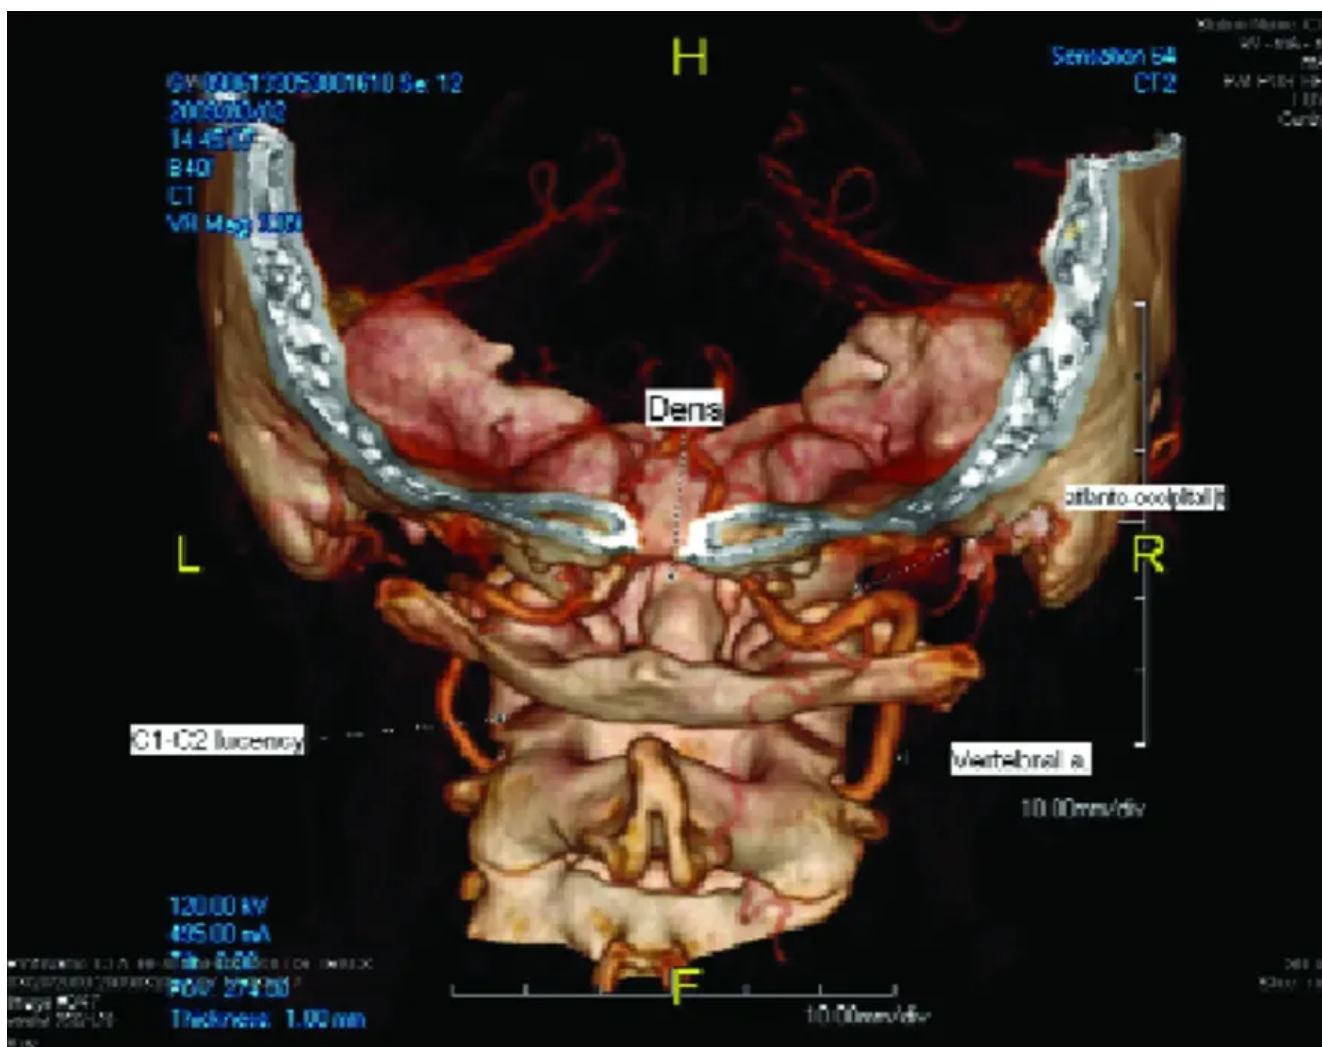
Figure 5. Reformatted CT angiogram demonstrating location of lateral and medial loops of vertebral artery relative to C0-C1 joint.*
